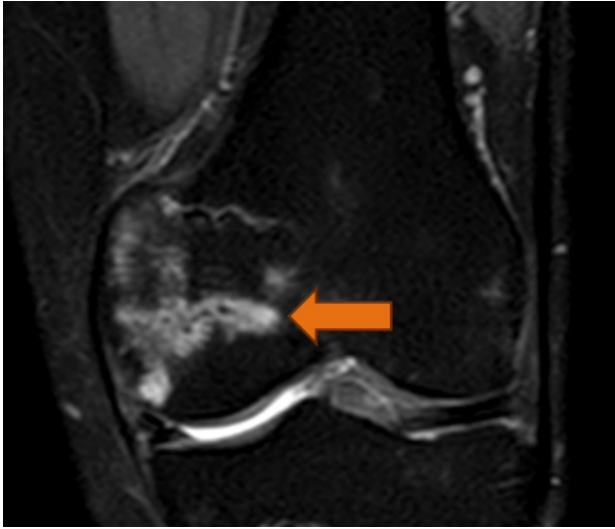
MRI of the left knee, STIR sequence. Fracture of the medial femoral condyle.
